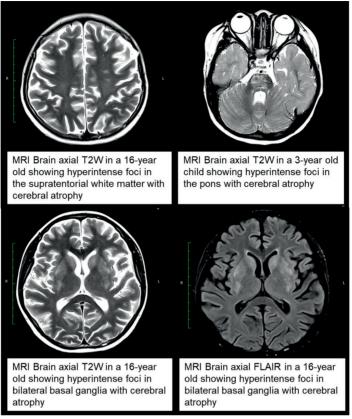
Magnetic resonance images of the patients with neuropsychiatric lupus.
